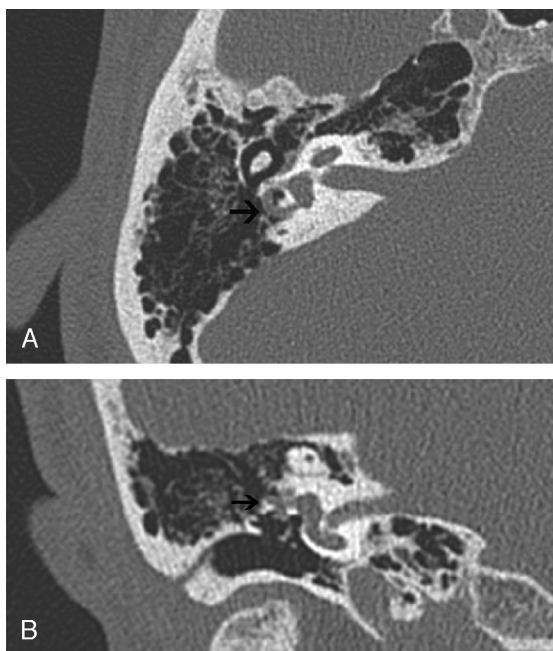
Axial (A) and coronal (B) CT scan of the right temporal bone reveals dehiscence of the bone over a large part of the lateral semicircular canal.
